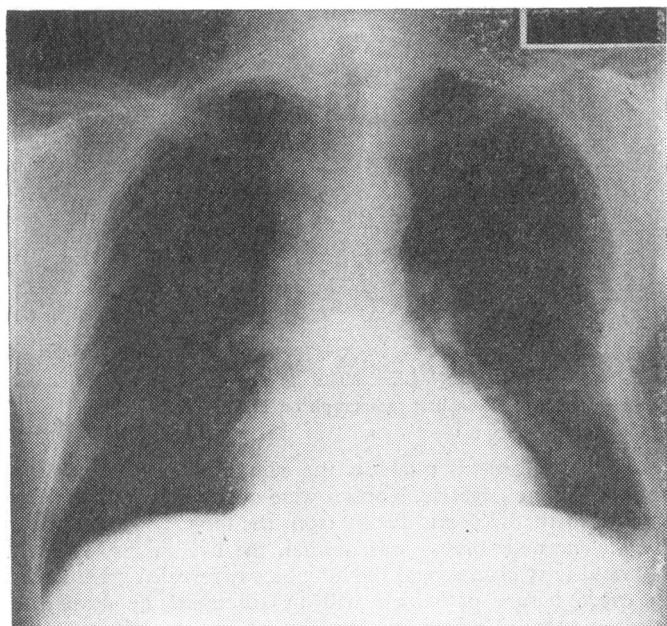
Chest radiograph 20 December 1966.
